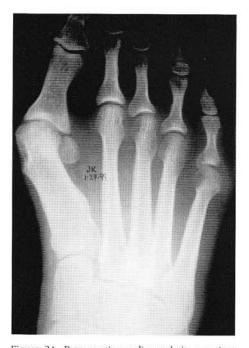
Preoperative radiograph in a patient with concomitant hallux limitus deformity and a recurrent HAV deformity. Some type of osteotomy was performed in the proximal diaphysis of the first metatarsal. The splaying between the first and second metatarsal was clinically fixed and rigid in nature.
